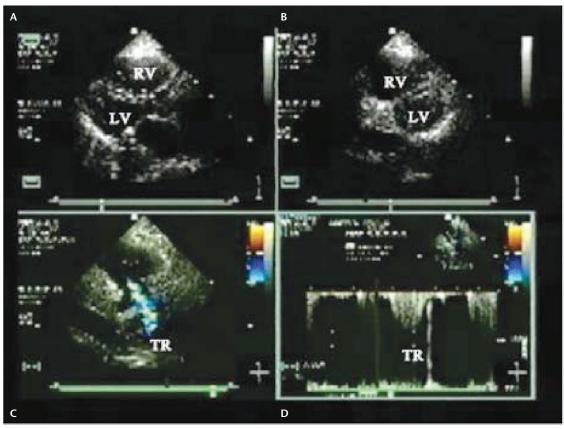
Echocardiography in acute PE. There is dilatation of the right ventricle (A) with diastolic bowing of the intraventricular septum (B), significant tricuspid regurgitation (C), and elevated right ventricular systolic pressure (D). LV: left ventricle; RV, right ventricle; TR, tricuspid regurgitation.
